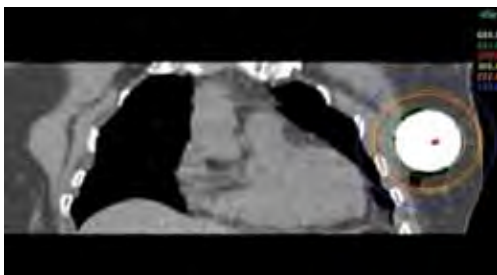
Coronal CT image of typical isodose lines achieved with the MammoSite brachytherapy device. Red line (340 cGy) represents the 100% dose line, 1 cm from the surface of the balloon.
